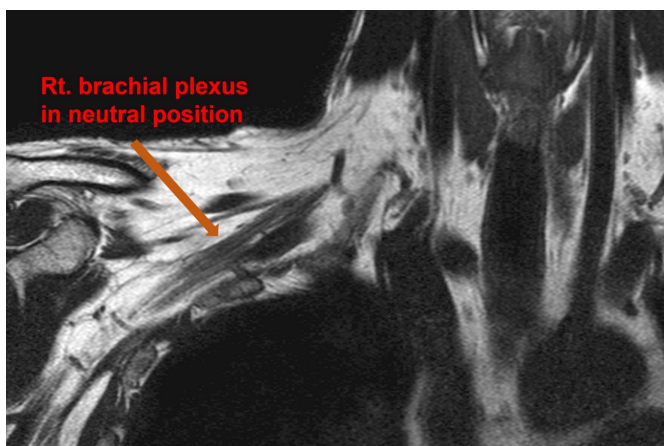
Magnetic resonance imaging in neutral position. Rt.: right.
